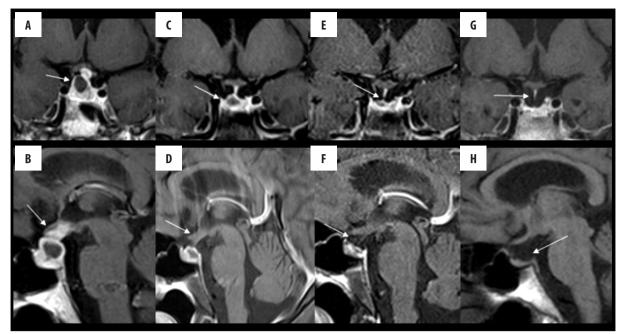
Serial MRI scans of the sella over 6 years, postcontrast (except G and H) coronal (top row) and sagittal images (bottom row) for comparative analysis. At initial presentation (A, B), the anterior lobe of the pituitary gland was enlarged with a solid-cystic appearance (arrow in A). Pituitary stalk was also thickened (arrow in B). At 4 weeks (C, D), a significant reduction in the size of the lesion (arrow in C) and thickness of the pituitary stalk are seen (arrow in D). (E, F) At 10 weeks, a near-complete disappearance of the mass with persistence of a tiny cystic remnant is seen (arrow in E). The height of the pituitary gland was also decreased with a flattened upper margin (arrow in F), unusual for a multipara. (G, H) At 6 years, a partial empty sella, thinned pituitary stalk (arrow in G, H) and absence of lesion were noted.
